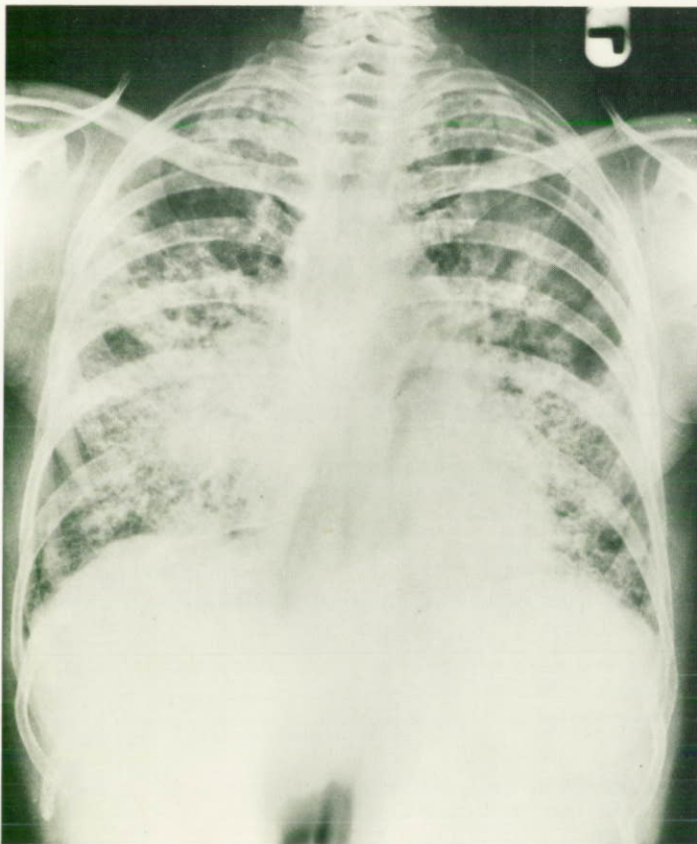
Chest radiographs in fibrosing alveolitis. There are multiple nodular opacities in both lung fields.
